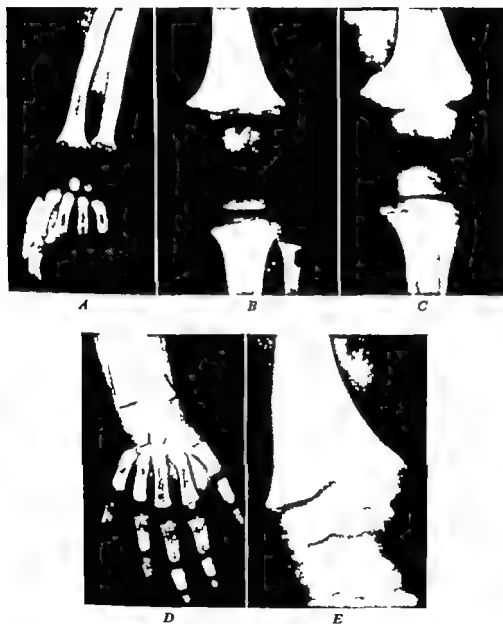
Vitamin D resistant rickets, familial type G. M, age 18 months at start of therapy. The series of bone roentgenograms indicate the progressive healing of active rickets when dihydrotachysterol (Hytakerol) was given as the only form of therapy. A July 31 1959 wrist, active rickets—start of therapy. B July 31 1957 knee active rickets. C Sept. 11 1957 knee, healing rickets, Hytakerol treatment. D Sept. 16 1958 wrist, healed rickets, 12 months after onset of treatment. E July 16 1958 knee healed rickets.
